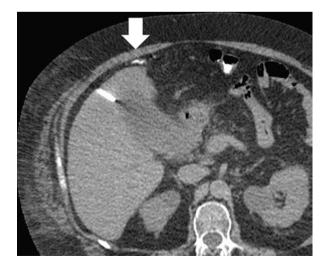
Needle placement during CT-guided percutaneous cholecystostomy. Note: Transhepatic tract and portion of colon anterior to liver (white arrow)
